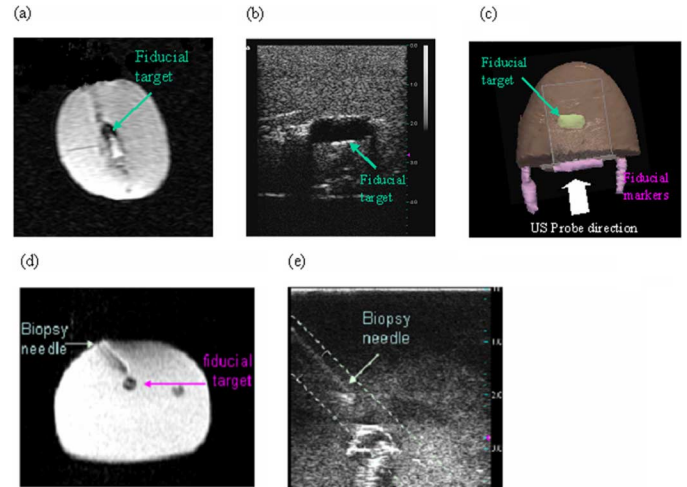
Simultaneous MR/US images of biopsy needle targeting. (a) MRI breast image with fiducial target in 3 T, (b) US image of the fiducial target with US in 3 T MRI system, (c) 2-D US image fused with a rendered MRI volume, with passive fiducial markers tracking in 3 T (d) MRI breast image in 0.5 T and (e) the corresponding US image with real time active tracking in 0.5 T.
